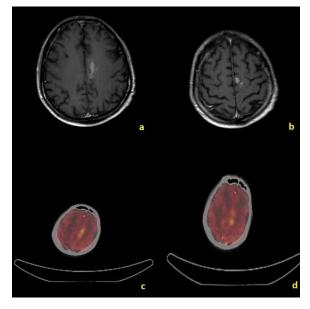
Imaging of Primary Central Nervous System Lymphoma as evolution of Lymphomatosis cerebri. T1-wheighed contrast enhanced sequences showed nodular lesions characterized by intense contrast enhancement in the cortex and subcortex of frontal left hemisphere (a,b). FDG-PET showed focal glucose hypermetabolism of the frontal lesions (c,d).
